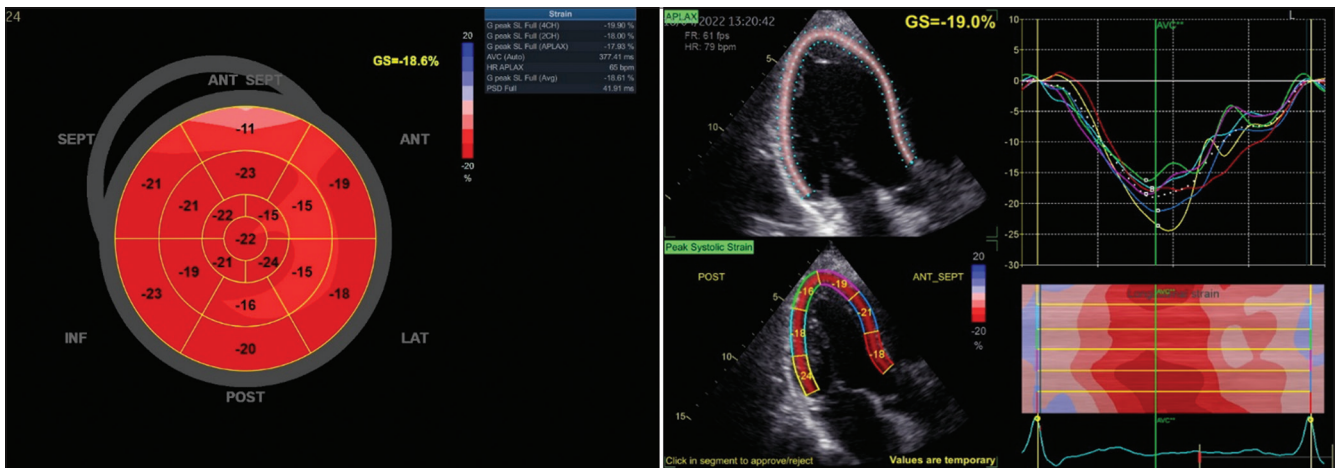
Speckle tracking echocardiographic showing global longitudinal strain in recovery
